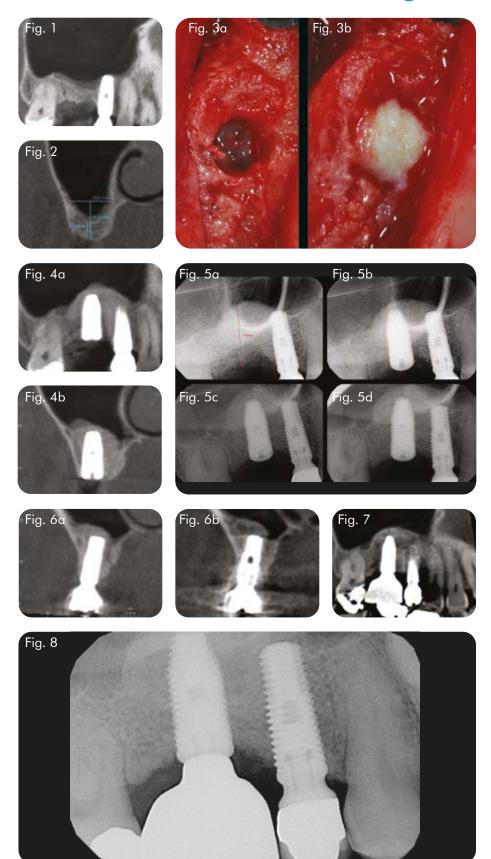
One year after surgery. Observing the radiograph, it's difficult to identify the transition between pristine and newly formed bone
